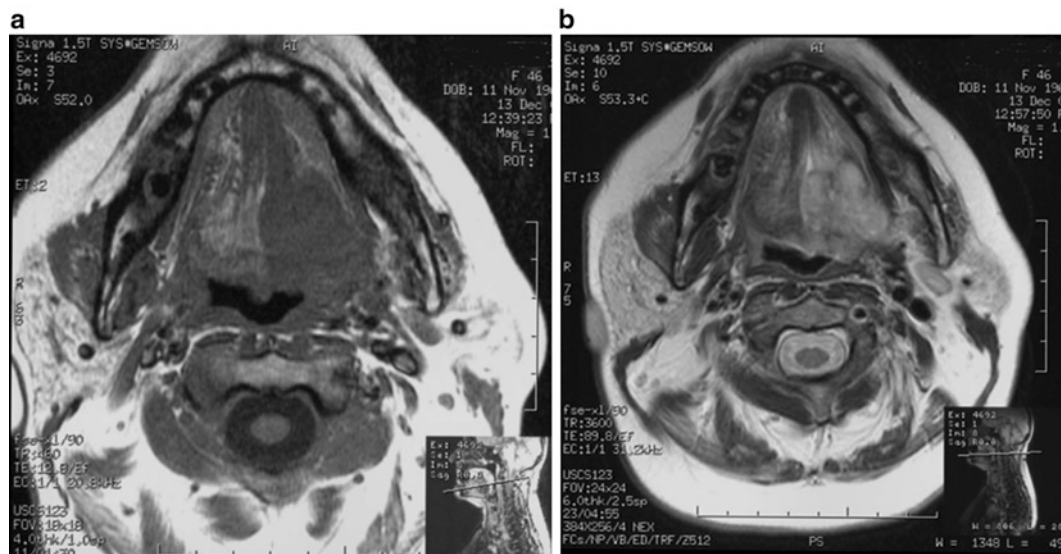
Squamous cell carcinoma of the tongue in a 48-years old female patient. The MRI shows the lesion extending and occupying the right side of the tongue. T1 weighting (a) and T2 weighting (b)
